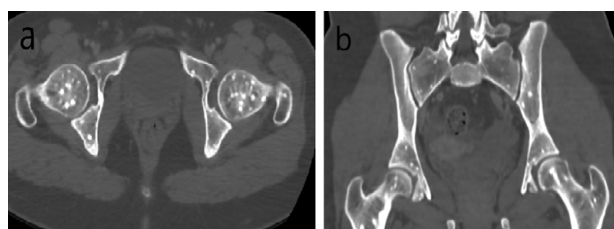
Abdominal-pelvic CT scan in axial section and coronal reconstruction showing dense, well-defined, and homogeneous round and oval islands at the sacrum, acetabulum, iliac wings, and femoral heads in Osteopoikilosis.
